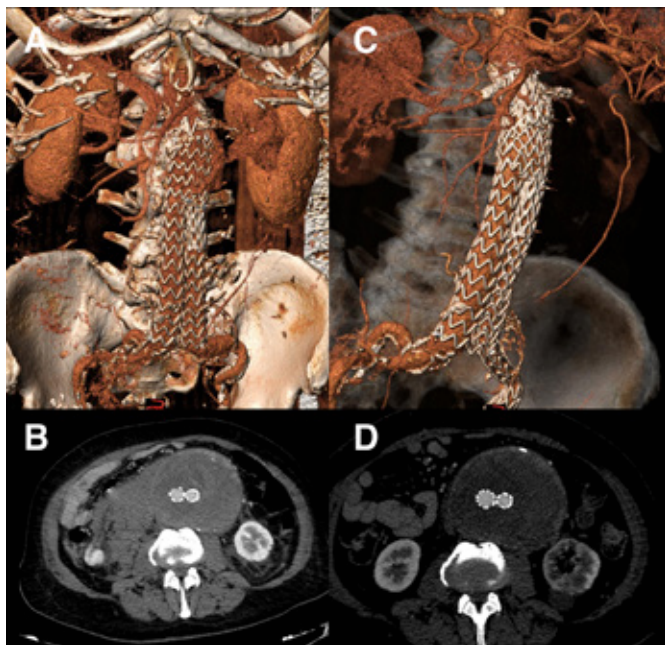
3D reconstruction (A) and axial (B) computed tomography angiography showing the ruptured pararenal abdominal aortic aneurysm. 3D reconstruction (C) and axial (D) computed tomography angiography 6 months after double chimney showing patent renal arteries with no sign of endoleak.
